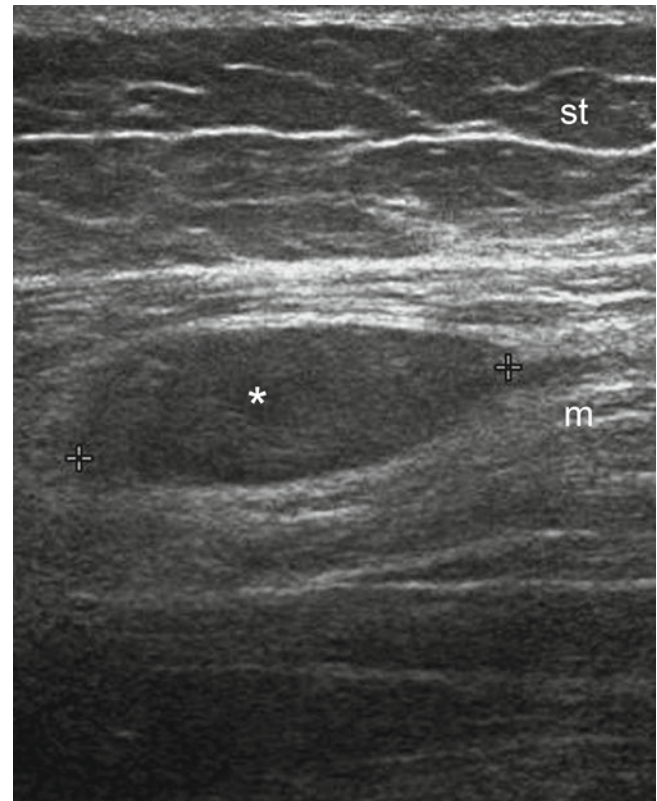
Intramuscular liquefied autologous fat. Grey scale ultrasound image (longitudinal view, left gluteal region) demonstrates a well-defined oval-shaped anechoic deposit (*) within the left gluteus maximus muscle. *Abbreviations: st* subcutaneous tissue, *m* gluteus maximus muscle
